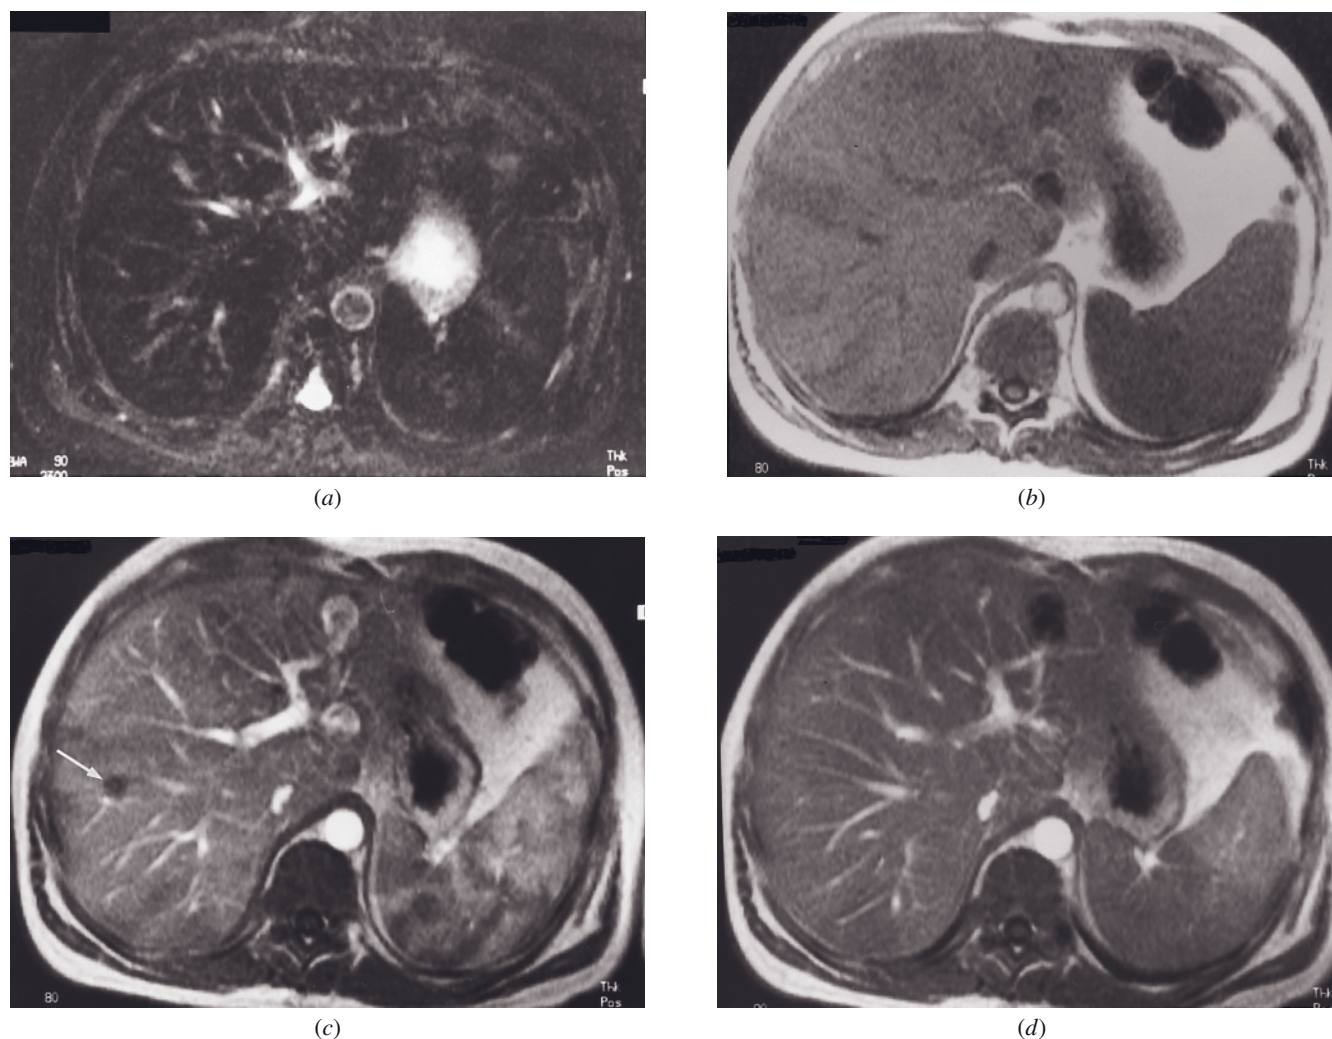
Hepatic lymphoma, low T2-weighted signal. Fat-suppressed T2-weighted SE (a), SGE (b), and immediate (c) and 90-s (d) postgadolinium SGE images. On the T2-weighted image (a), the liver and spleen demonstrate transfusional siderosis with low signal intensity of the liver and spleen. The SGE image (b) demonstrates wedge-shaped regions of low signal intensity representing increased iron deposition. On the immediate postgadolinium image (c), focal low-signal intensity masses (arrow, c) of diffuse histiocytic lymphoma are shown. These masses enhance to isointensity with hepatic parenchyma on interstitial-phase images.
